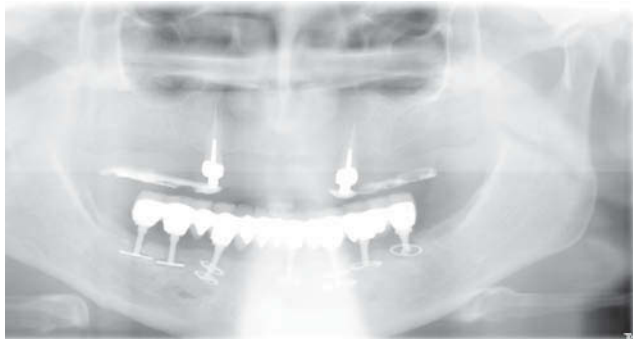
The first radiographic picture after the patient had been out of control for more than 3 years after the placement of the prosthetical workpiece (2000)
